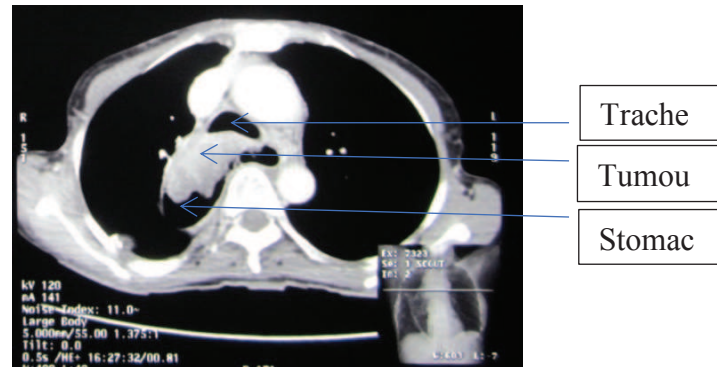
CT scan of the chest showing the tumour in the stomach and, indenting the trachea
